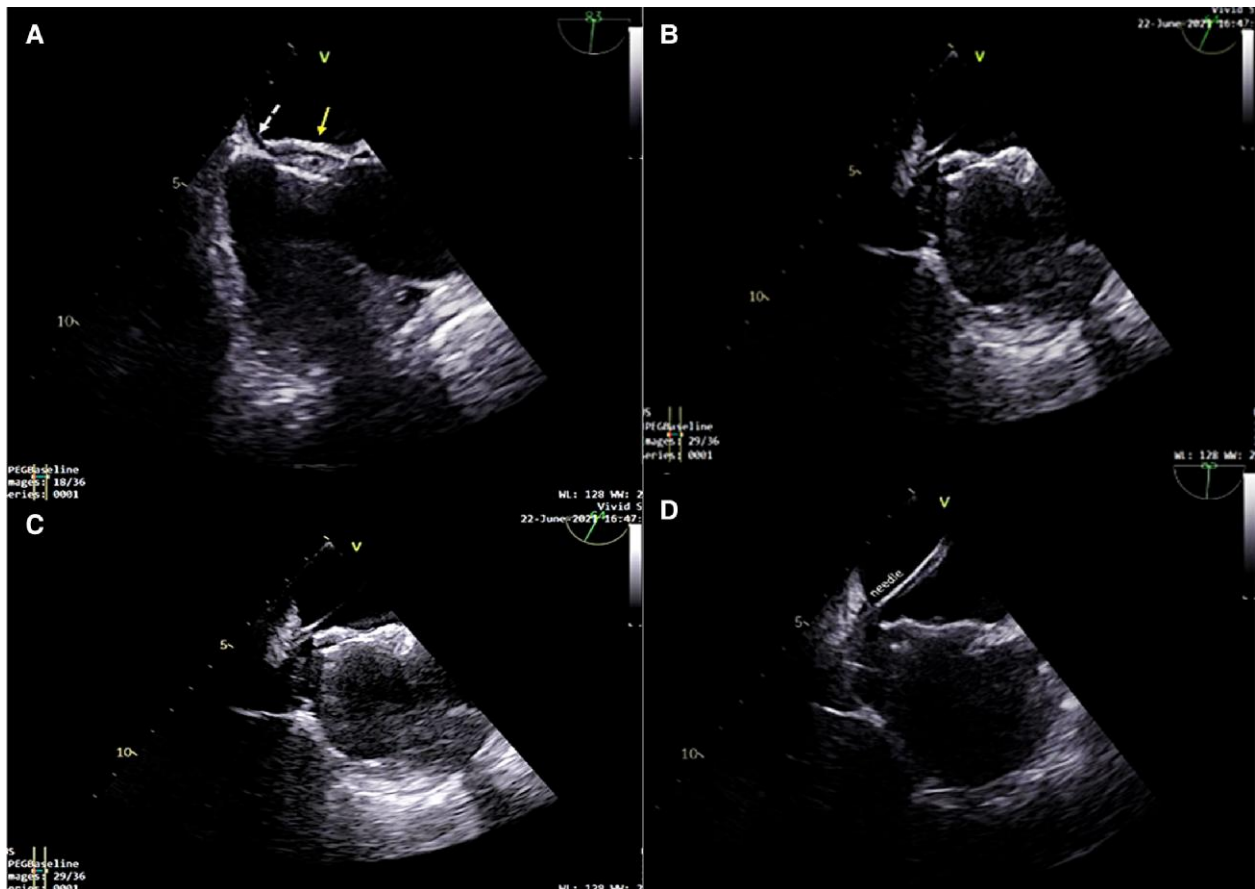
Sequence of transesophageal echocardiography images showing the Amplatzer device location (A, unbroken arrow), the site to perform the transeptal puncture (A, dashed arrow), and the Brockenbrough needle progression (Medtronic, Minneapolis, MN) (B, C, and D).
